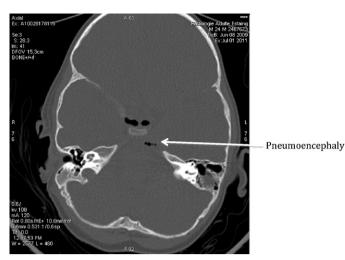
Axial bone window CT-scan of skull base shows pneumoencephaly.
